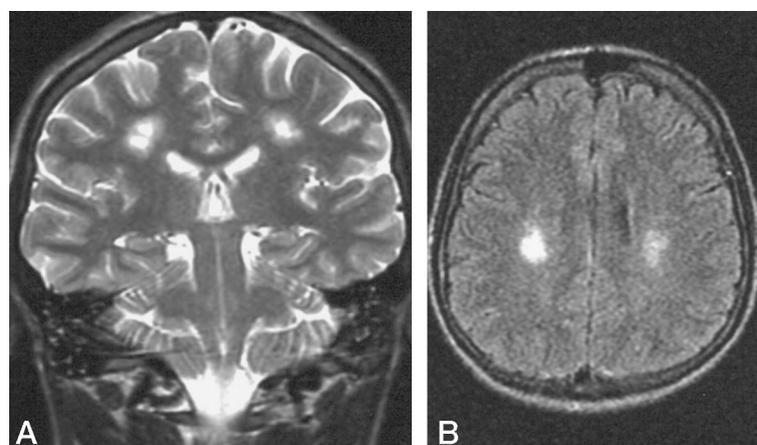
Case 3: White matter gliosis. Coronal fast spin-echo T2-weighted MR image (4700/102) (A) and fast FLAIR image (10,000/145; TI = 2200) (B) obtained 4 weeks after the onset of cerebral malaria show bilateral foci of hyperintensity in the centrum semiovale. There was no enhancement on T1-weighted contrast-enhanced images (not shown).
